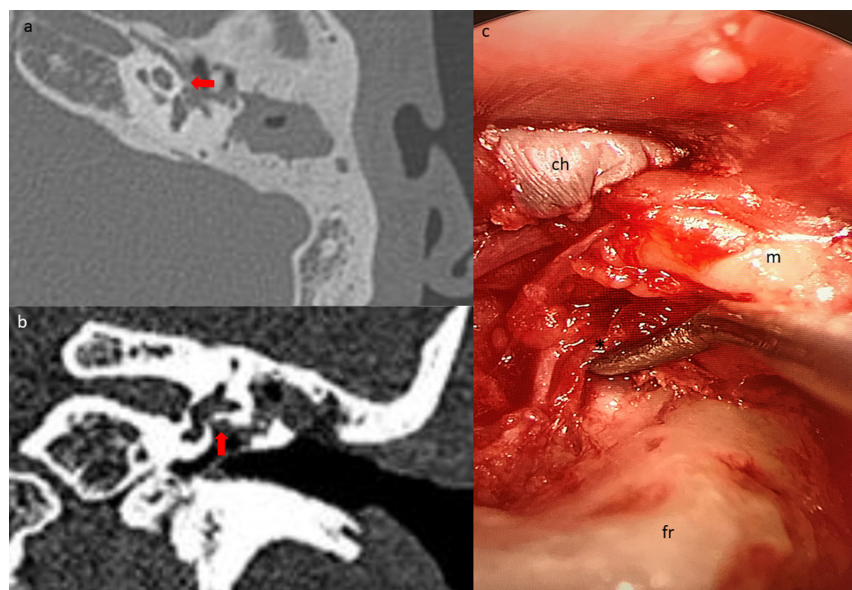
The preoperative high-resolution computed tomography of the temporal bone for case 2 showed dehiscence facial canal over distal tympanic segment of the facial nerve as shown in the axial view (A) and the coronal view (B). Endoscopic view of the intraoperative findings for case 2 showed hanging dehiscence facial nerve (*) over the stapes suprastructure, which covered with granulation tissue with evidence of high facial ridge (C). ch, cholesteatoma; fr, facial ridge; m, malleus.
